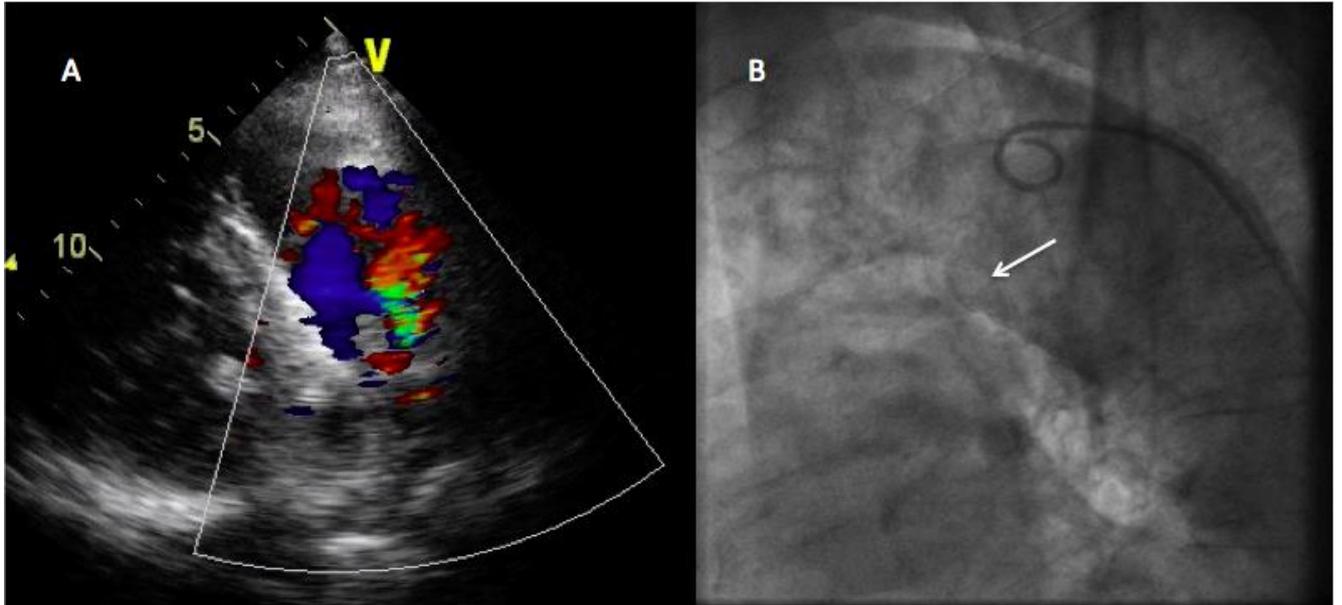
A) Echocardiography showing Doppler- color signal corresponding with PDA. B) Angiography with a white arrow pointing the PDA.
